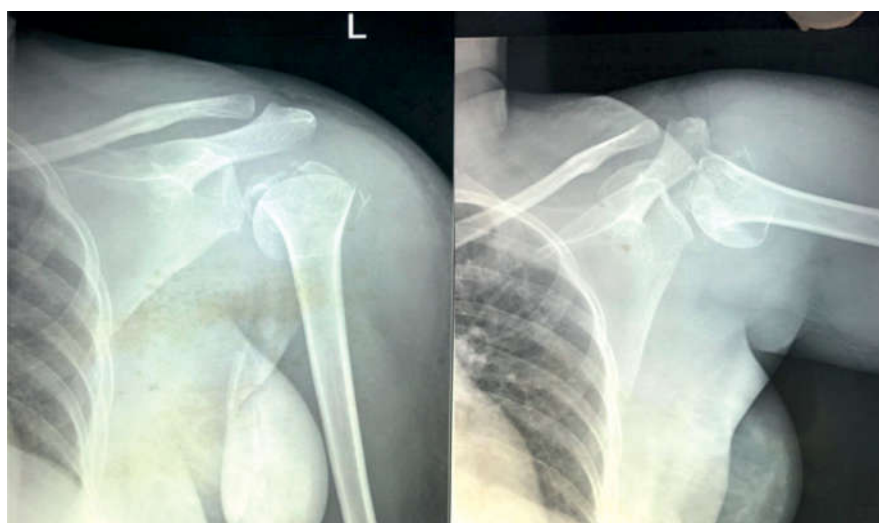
Humerus with shoulder joint plain radiographs shows: proximal 1/3rd humerus comminuted fracture near classification {4 part fracture - 3parts are displaced with respect to 4th part}.
